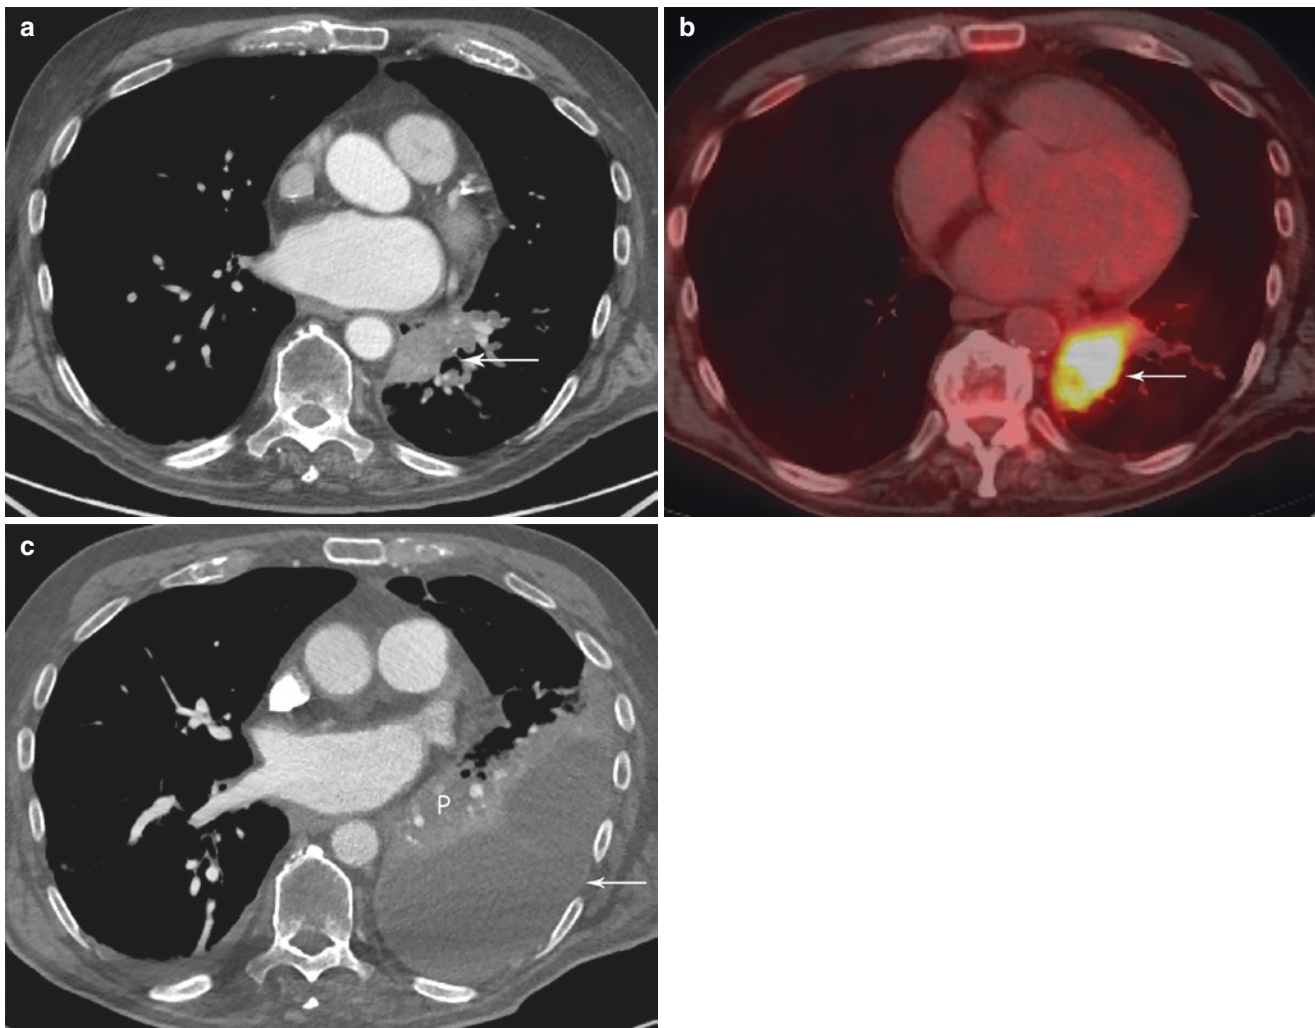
(a) Contrast-enhanced axial CT shows left lower lobe mass-like consolidation (arrow); (b) axial FDG-PET/CT shows increased FDG uptake in the consolidation suspicious for malignancy (arrow); (c)
